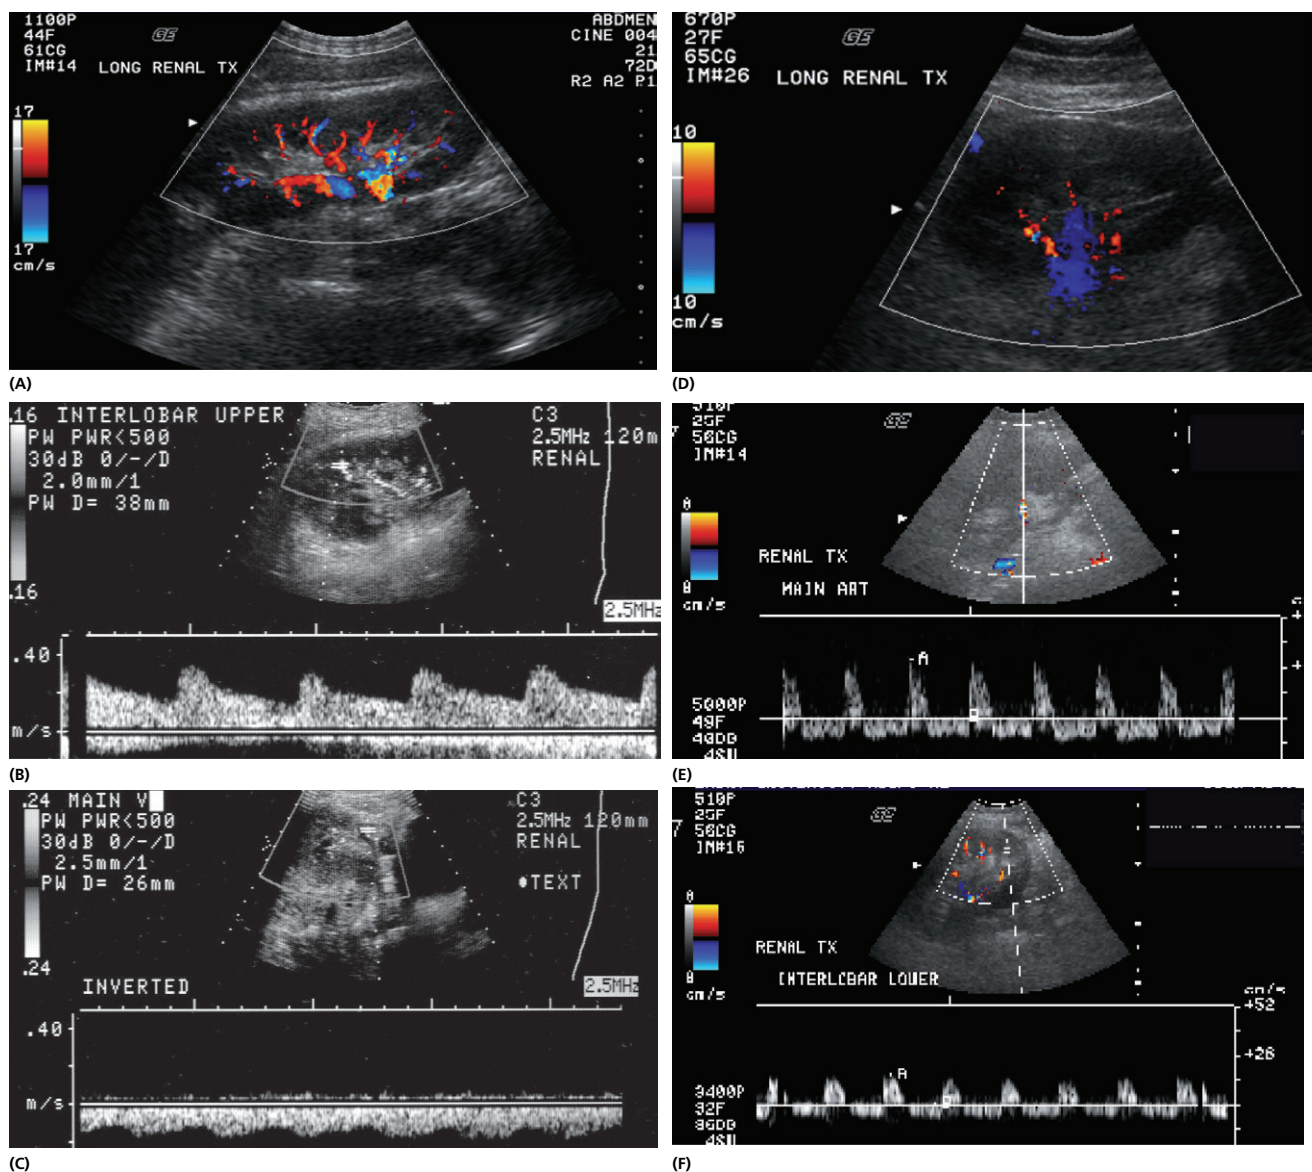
Ultrasound visualization demonstrating normal flow (A, B, and C) and the findings characteristic of venous thrombosis (D, E, and F). Note that in the normal situation, there is (A) a bright Doppler signal throughout the entire kidney, (B) a brisk upstroke of the arterial waveform with continuous flow through diastole, and (C) an easily detected continuous venous waveform. It is important to note that during venous thrombosis, (D) there may still be some flow detectable in the graft, although it is attenuated, (E) the arterial waveform may be present, but the arterial diastolic flow is reversed, and (F) no consistent waveform for the vein is seen (in this case an interlobar artery is seen with reversal of diastolic flow). Importantly, detection of flow without characterization of the proper waveforms *does not* rule out a vascular thrombosis.
